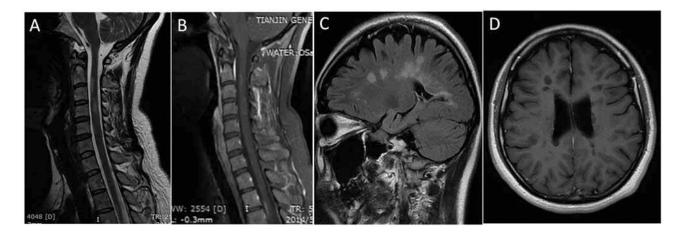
Opticospinal multiple sclerosis (MS) and conventional MS in an Asian population. A and B. Opticospinal MS in a Chinese female with a history of visual disturbance who presented with weakness in the lower extremities and impaired balance. Serum anti-aquaporin-4 antibody was negative. Visual evoked potentials showed an increased P100 latency on the right side. Brain MRI showed minimal white matter lesions. The cervical spine MRI showed numerous T2 lesions, none of which had the features of longitudinally extensive spinal cord lesions (A), and some of which showed enhancement following administration of gadolinium (B). C and D. Conventional MS in a Chinese female with a remote history of visual decline and pain around her left eye who presented with ataxia and falls. She had conventional Western-type MS with numerous periventricular lesions featuring Dawson's fingers (C) and "block holes" on T1-weighted MRI.
